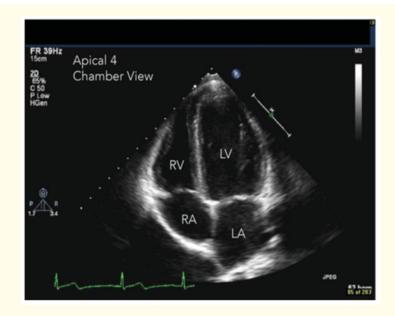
Apical four chambered view of adult heart.
